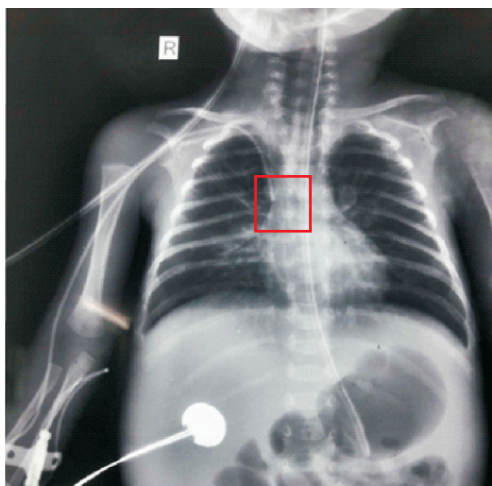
Anteroposterior radiograph of chest showing satisfactory position of PICC line (red box) inserted in the right upper limb.
